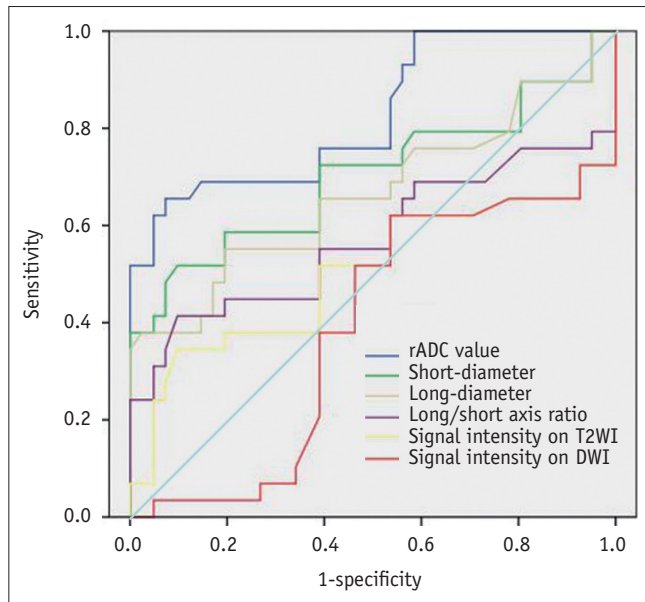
Graph shows that receiver operating characteristic curve for rADC value is superior to size-based criteria (short-diameter, long-axis diameter, and long/short-axis ratio) and signal intensity on T2WI and DWI for differentiation of inflammatory from metastatic lymph nodes. DWI = diffusion-weighted imaging, rADC = relative apparent diffusion coefficient
